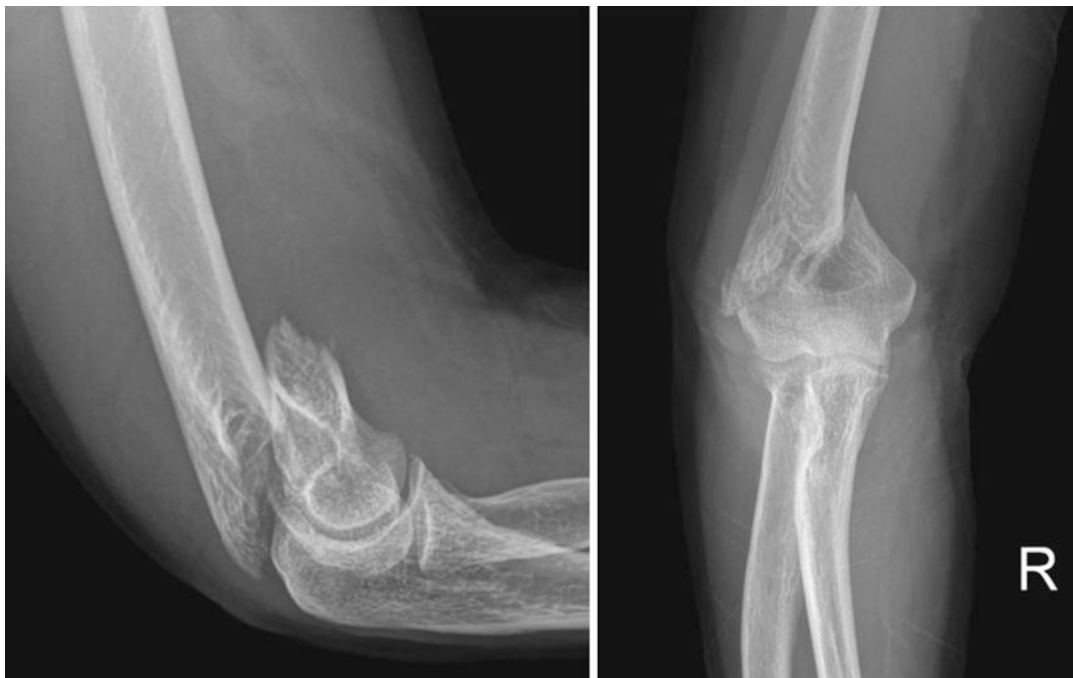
Anteroposterior and lateral radiographic view of AO/OTA type A2 fracture
